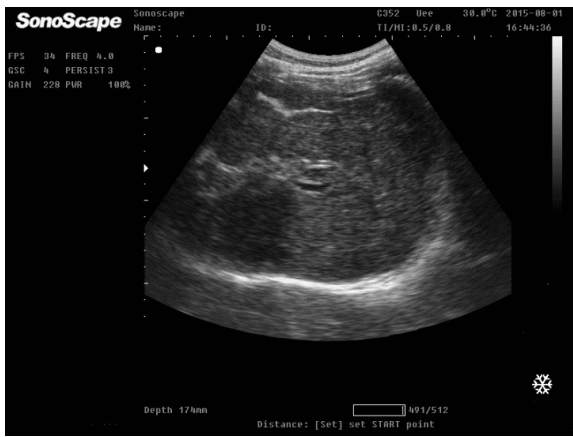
Abdominal ultrasonography reveals cirrhotic liver with complete portal vein thrombosis.
